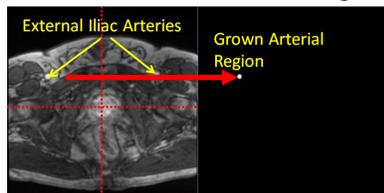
Left: Four square regions on 3D MRI, Right: Grown region.
